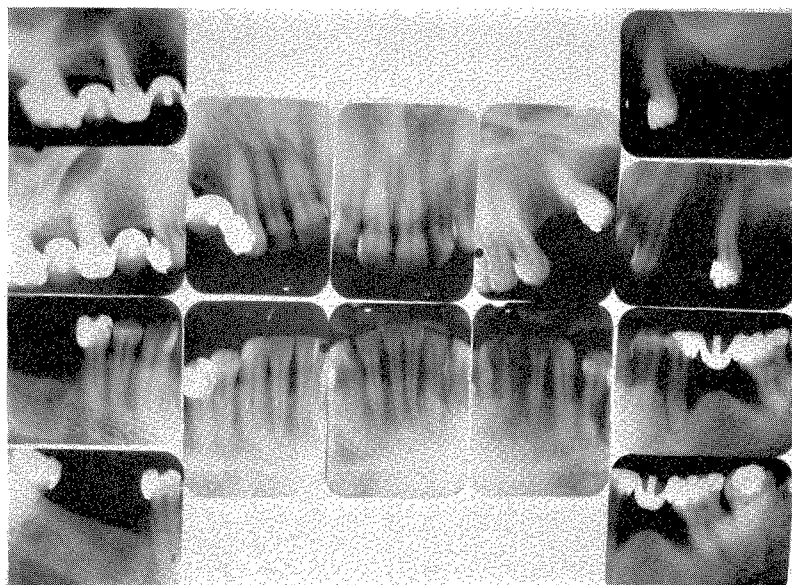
Roentgenograms taken in 1933. The patient was 35 years old. The periodontal pathology is very evident. (Figs. 157 to 180 are of the same case.)
